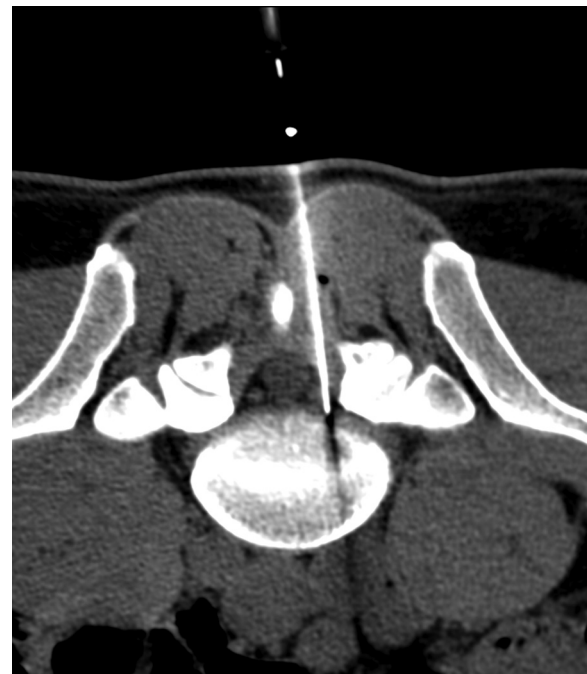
CT scan. The image shows a spinal needle inserted through interlaminar access. The right spinal nerve root is medial to the needle tip.
